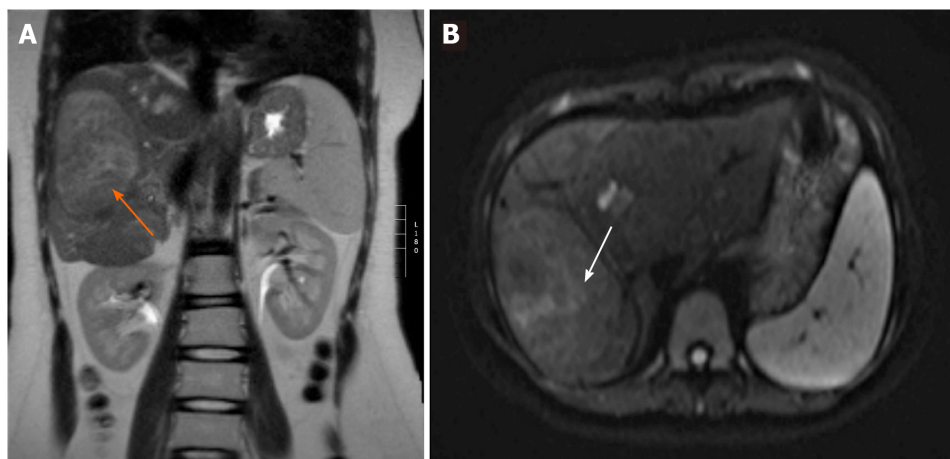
Abdominal magnetic resonance imaging scan demonstrating a lesion in the right liver lobe (case 5). A: The lesion (orange arrow) is slightly hyperintense compared to the surrounding liver tissue on coronal T2-weighted imaging; B: The same lesion (white arrow) has no restriction of diffusion on axial diffusion-weighted imaging (DWI) sequence - a benign lesion.
